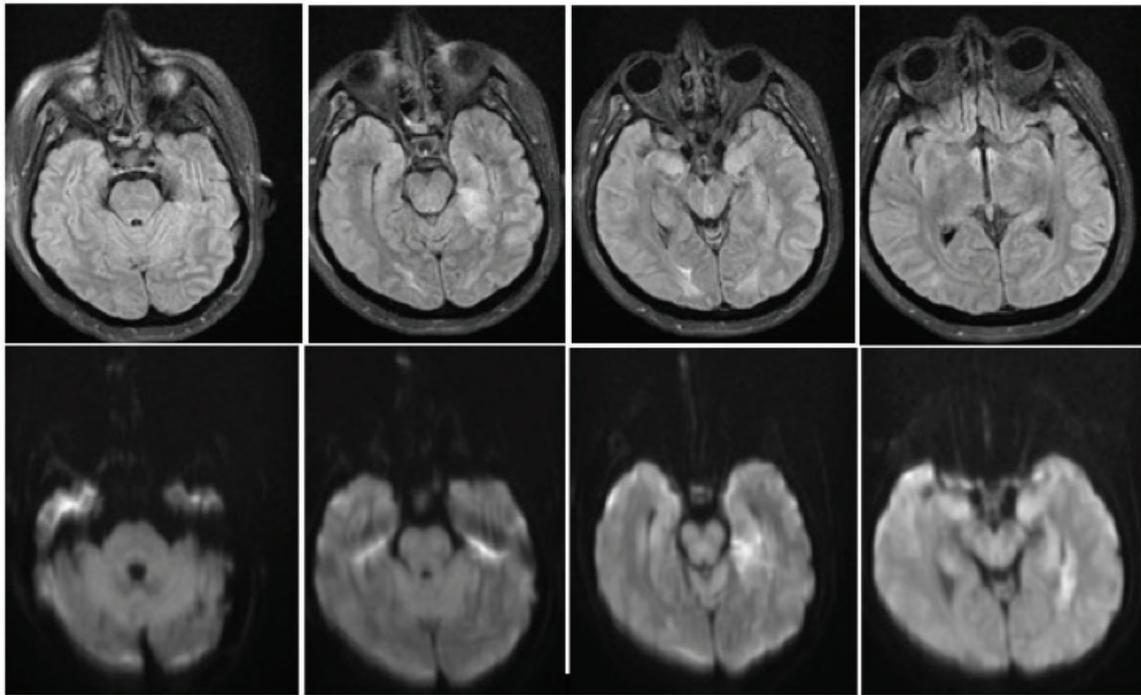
Patient's first Brain MRI Findings.
